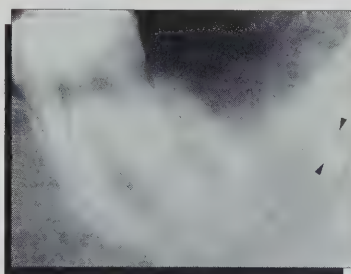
Radiographie prise immédiatement après l'extraction chirurgicale. Remarquez la gutta encore présente.
